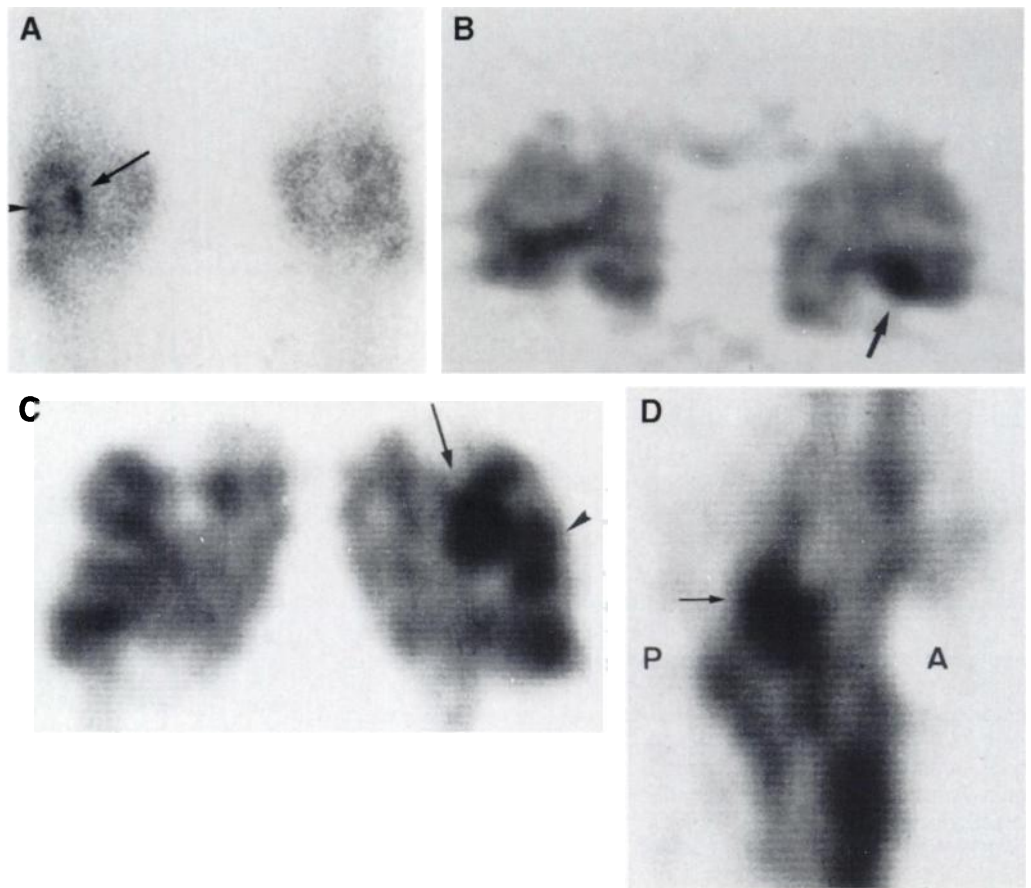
A 32-yr-old man, 6 mo after injury to the left knee. (A) Posterior planar image shows a focal area of increased activity on the medial aspect of the lateral femoral condyle on the left (arrow), at the site of ACL insertion. (B) transaxial (through the femoral condyles), (C) coronal and (D) sagittal slices show an area of increased activity on the medial aspect of the lateral femoral condyle posteriorly in the position of the upper attachment of the ACL (arrow). Further abnormality is seen in the lateral compartment of the knee (A, C) (arrowheads) corresponding to a lateral meniscal tear which was identified on MRI.
